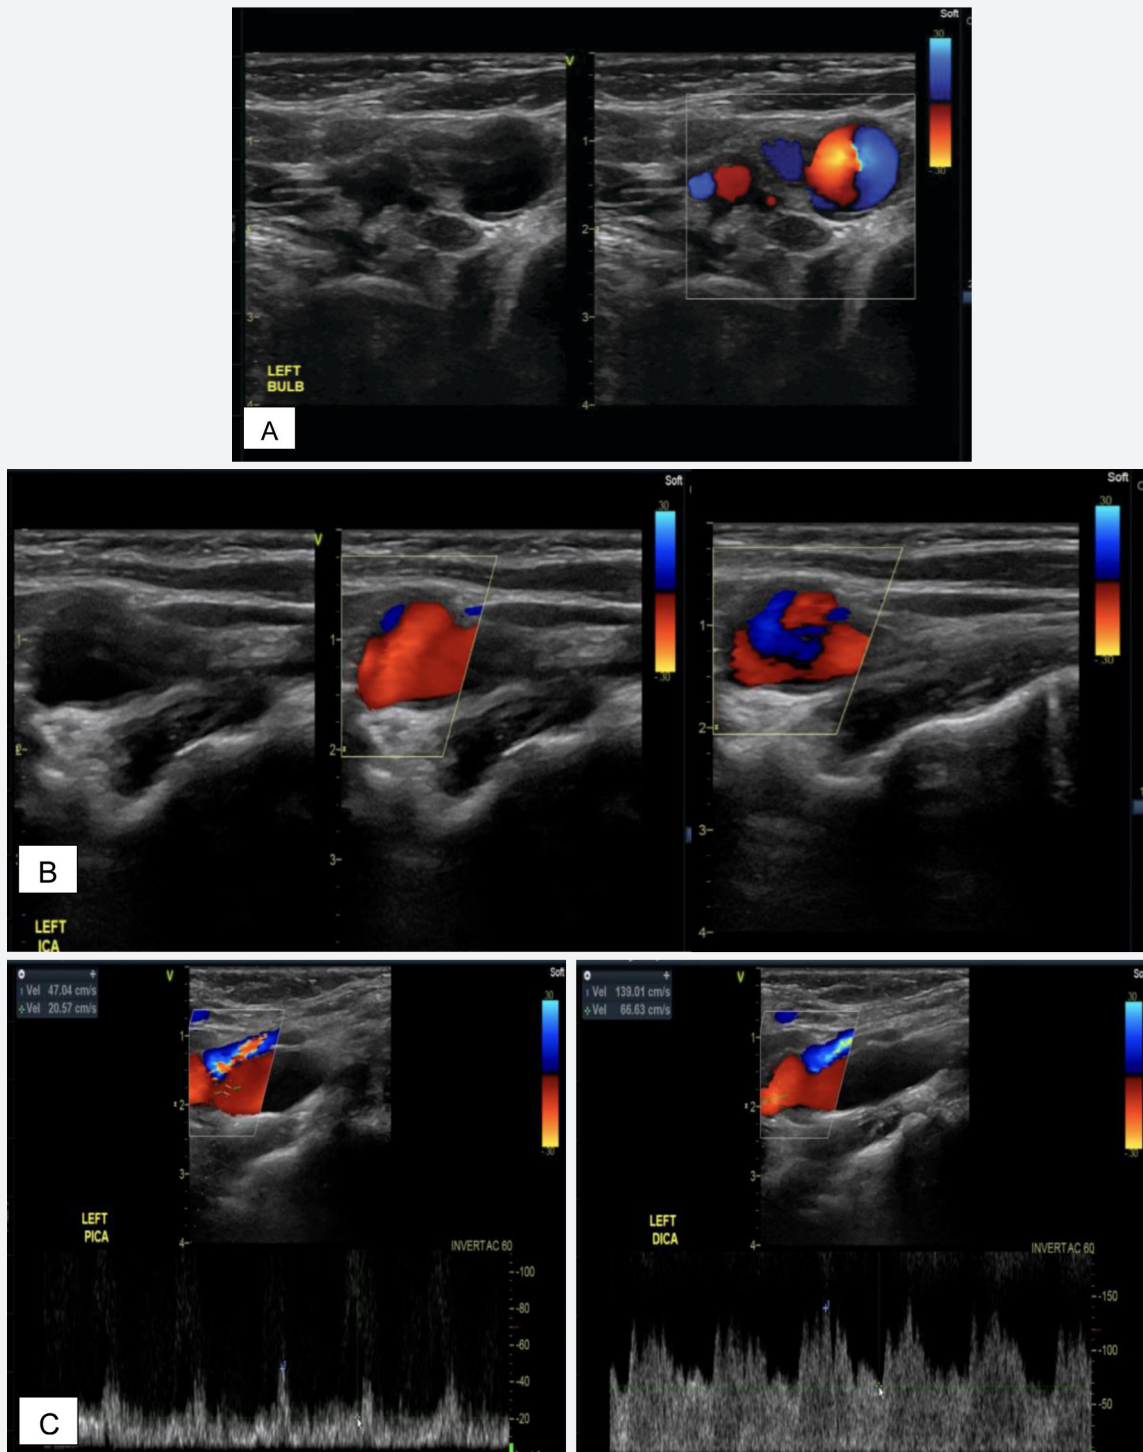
Carotid duplex scan of the left internal carotid artery. A. Short axis view B. Long axis view C. Doppler study showed an increase in the peak systolic velocity from the proximal going to the distal ICA due to looping.
